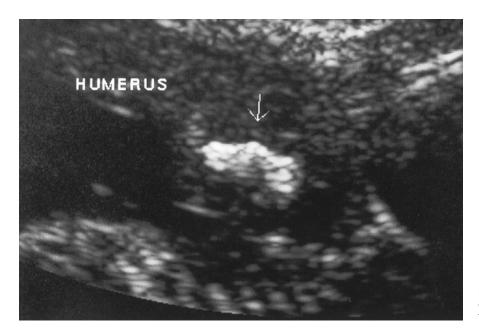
Sonographic image of an acutely angled humerus in a fetus with type II OI.
